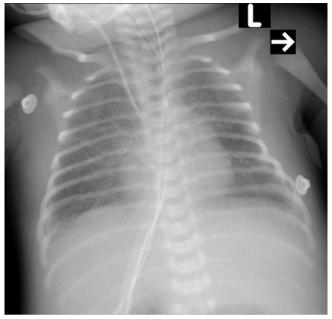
X-ray chest of a neonate on the 1st day of postnatal life showing uniformly aerated lungs with some interstitial densities
